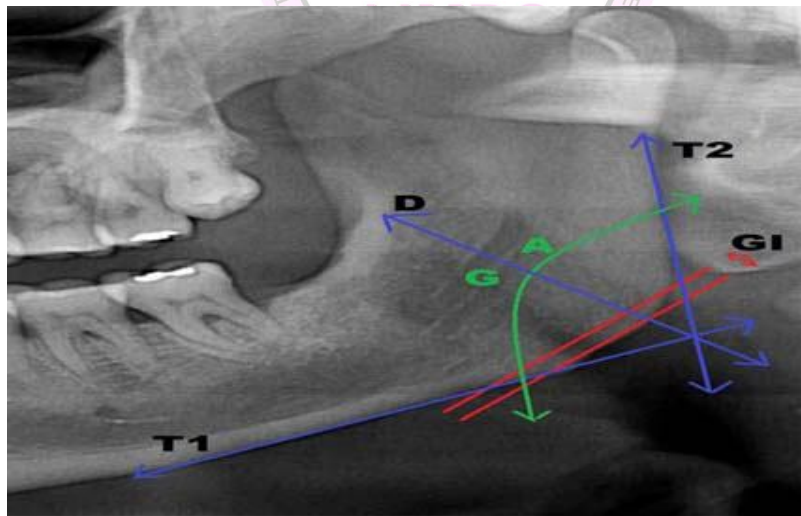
Magnified view of a part of an orthopantomograph depicting the method of measuring Gonial Angle (GA) and Gonial index (GI): T1 – Line tangent to the lower border of the mandible. T2 – Line tangent to the posterior border of ramus of the mandible. D – Bisectrix of the angle formed between T1 and T2 i.e. GA or Gonial Angle. GI – Mandibular cortical thickness measured on D.
